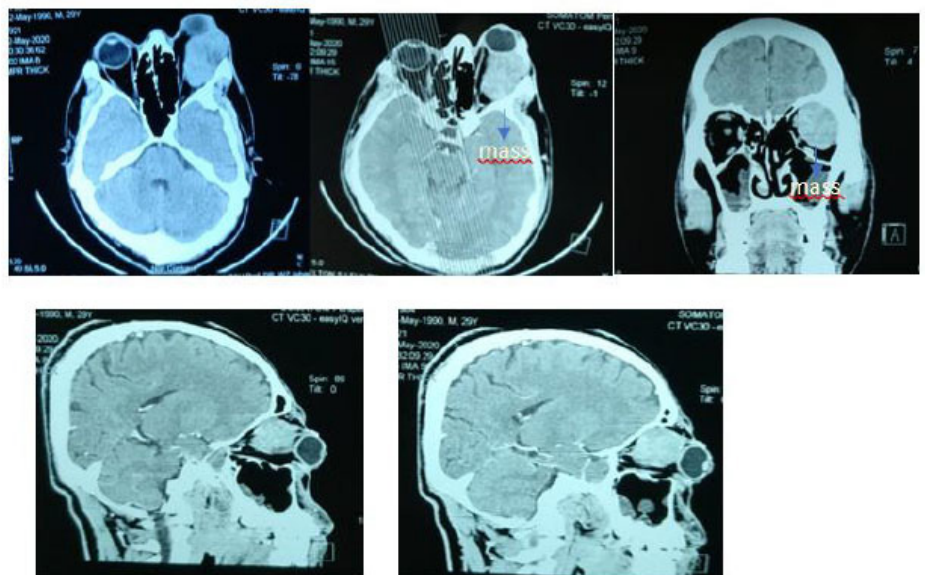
Head CT Scan with and without contrast at Prof. Hospital. WZ Johannes Kupang on May 12, 2020, after experiencing a worsening.
